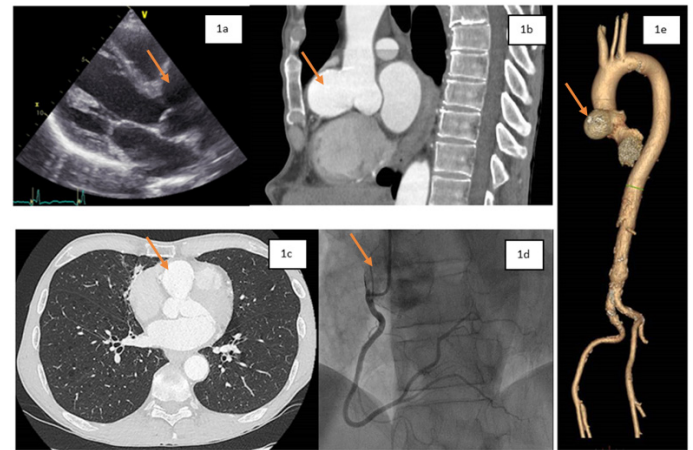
The aneurysmal dilatation of the right coronary sinus (arrow) on TEE at parasternal long axis view (1a); (1b). Sagittal plan of the cardiac CT (arrow on the right coronary sinus); (1c). Axial plan of the cardiac CT (arrow on the right coronary sinus); (1d). Right coronary artery with view of the right sinus of Valsalva (arrow) on coronary angiography; (1e). Three-dimensional CT displaying the aneurysm (arrow).
